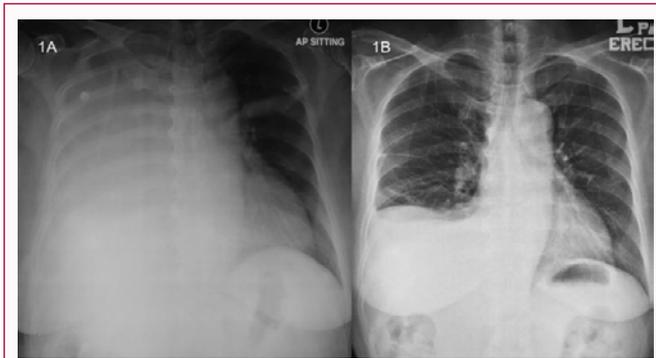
A - Chest radiography during first presentation showed massive right sided pleural effusion. B - Chest radiography showed resolving right sided pleural effusion during follow up.
